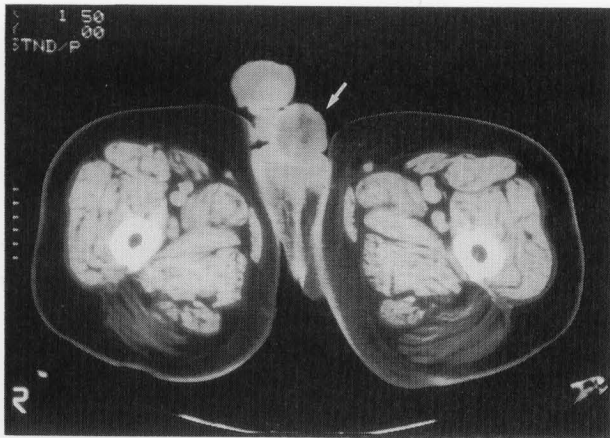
CT with contrast media reveals a heterogeneous, low-density mass at the base of the penis (arrow).
